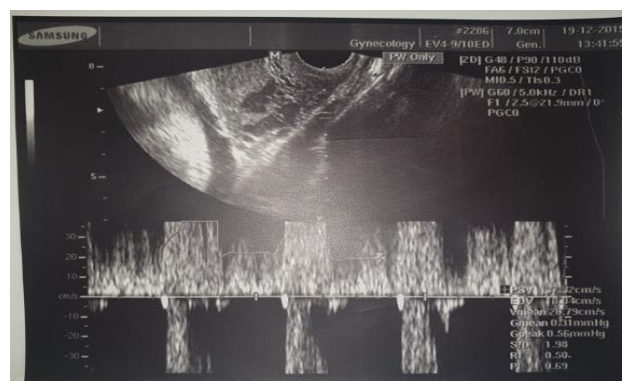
Uterine artery Doppler velocimetry (pulsatility index= 0.69).
